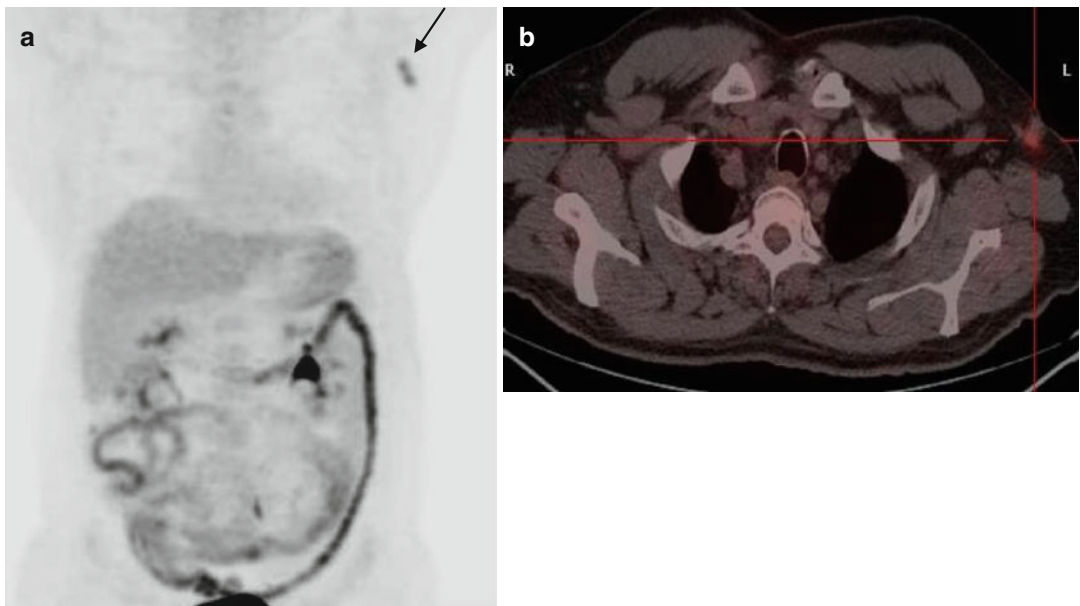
(a, b) Interim PET/CT. Abnormal 18-FDG uptake (SUVmax 4.5) was noted in a residual left axillary node. The uptake exceeded that of the liver corresponding to a Deauville 5-point scale score 4
